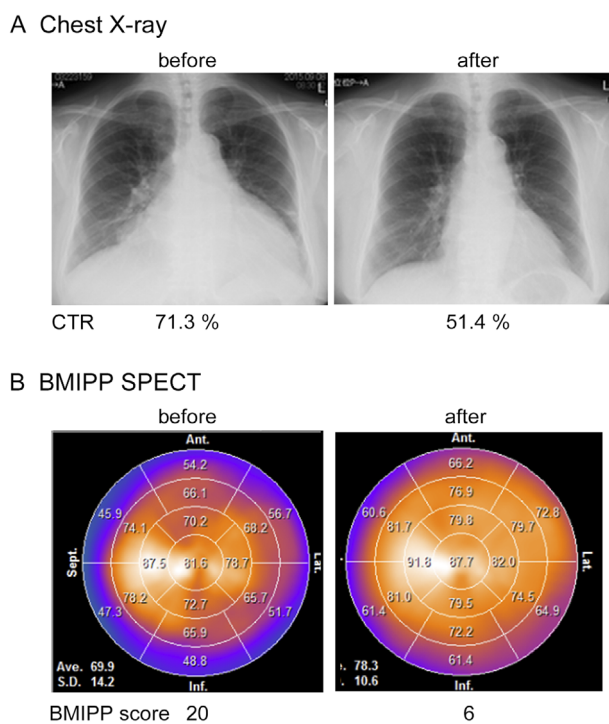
Images of chest X-ray (A) and BMIPP SPECT (B) before and after L-carnitine administration. (A) L-carnitine administration resulted in a decrease in the CTR from 71.3% to 51.4%. (B) The administration also resulted in the decrease of BMIPP summed scores from 20 to 6, indicating that the myocardial fatty acid metabolism was improved. The BMIPP summed scores were calculated using a 17-segment 5-point system (normal, 0; absent, 4). The range of BMIPP summed scores was 0-68. BMIPP: β -methyl-*p*-iodophenyl-pentadecanoic acid, CTR: cardiothoracic ratio, SPECT: single-photon emission computed tomography
